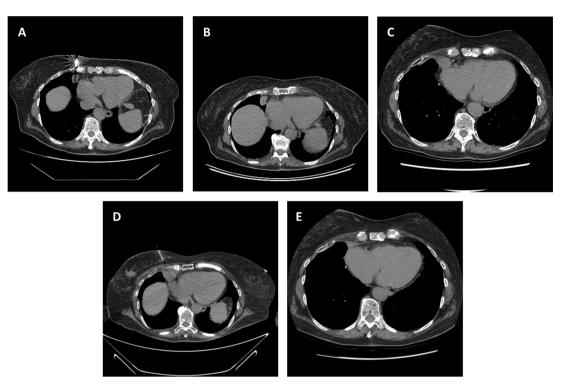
A. Images from computed tomography (CT)-guided biopsy of adenocarcinoma lung lesion at the time of diagnosis. B. Chest CT before right middle lobectomy and adjuvant carboplatin-pemetrexed. C. Chest CT 5 months after right middle lobectomy and 1 month after last cycle of carboplatin-pemetrexed. D. CT-guided biopsy of squamous cell lung cancer progression. E. Images from chest CT 1 month after initiation of erlotinib with lesion now 1.9 × 0.8 cm, previously 2.4 × 2.0 cm.
